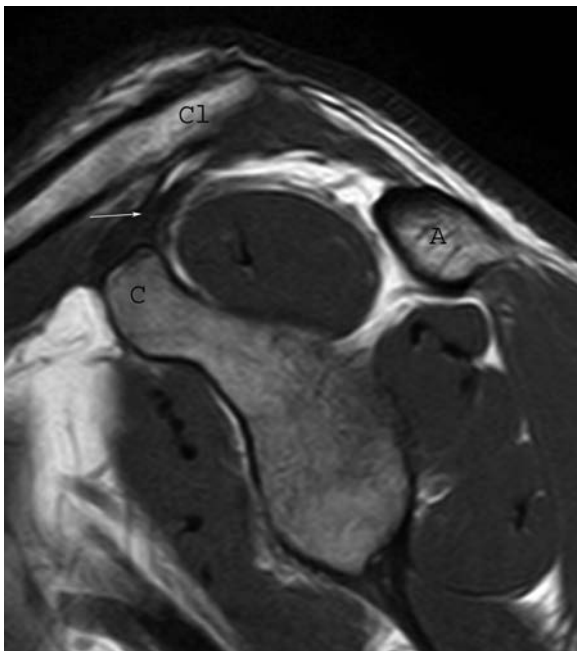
Sagittal T1-weighted image shows coracoclavicular ligament. A, acromion; C, coracoid process; Cl, clavicle. Arrow shows conoid of coracoclavicular ligament.
